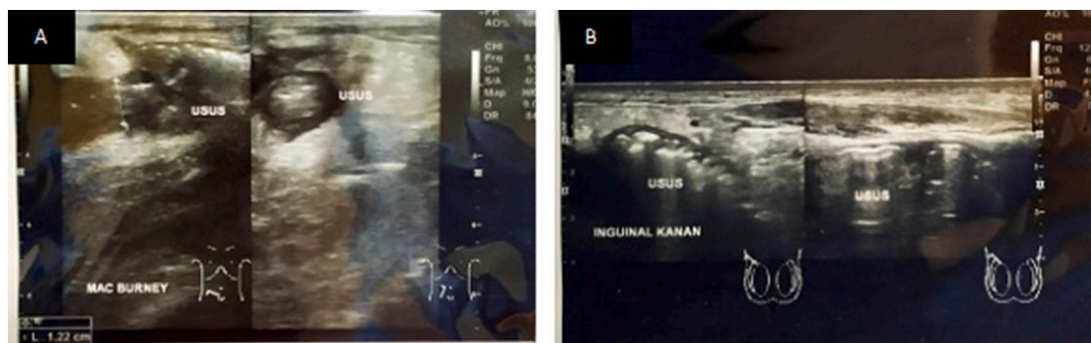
Ultrasound examination of the abdomen (A) and testicle (B) with suspicion of intestine in the Mcburney area and inside the scrotum.
